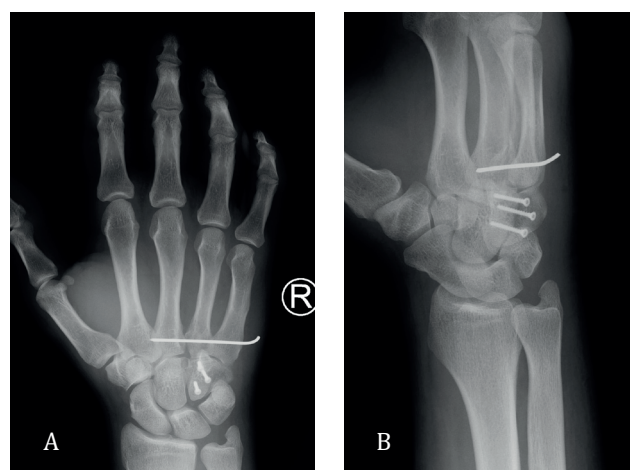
X-ray of the hand and wrist showing 3 transfixing ulnar metacarpals and hamate: A – p-a view; B – lateral view
